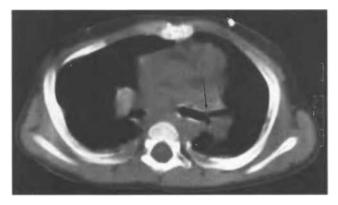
CT scan of a patient with a stent in place. There is granulation tissue growing over the distal end of the stent (arrow)
